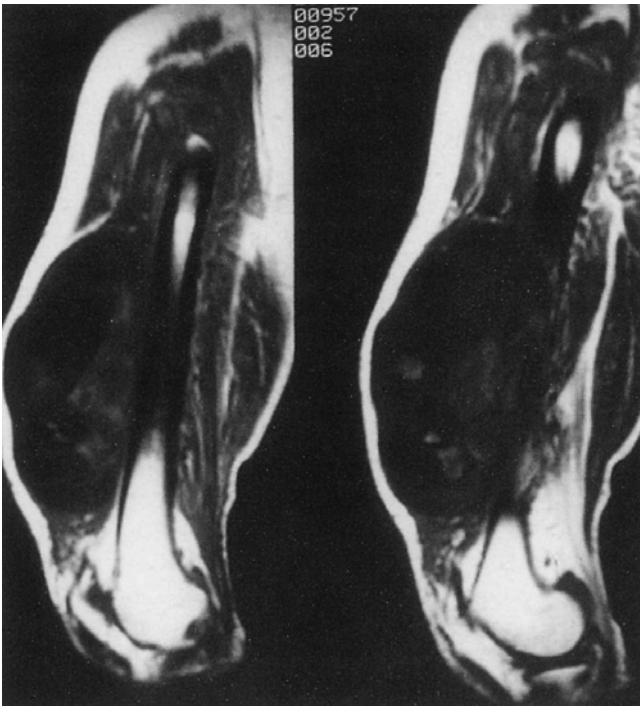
MRI scan of Ewing's sarcoma showing large extraosseous mass
